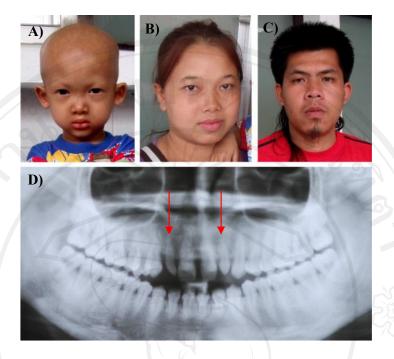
Phenotypes of members in the Family III. Facial appearance of A, proband (CGL DNA No.813) B, mother of the proband (CGL DNA No.807) and C, father of the proband (CGL DNA No.808). D, panoramic radiograph of the proband's mother shows two peg-shaped teeth.
